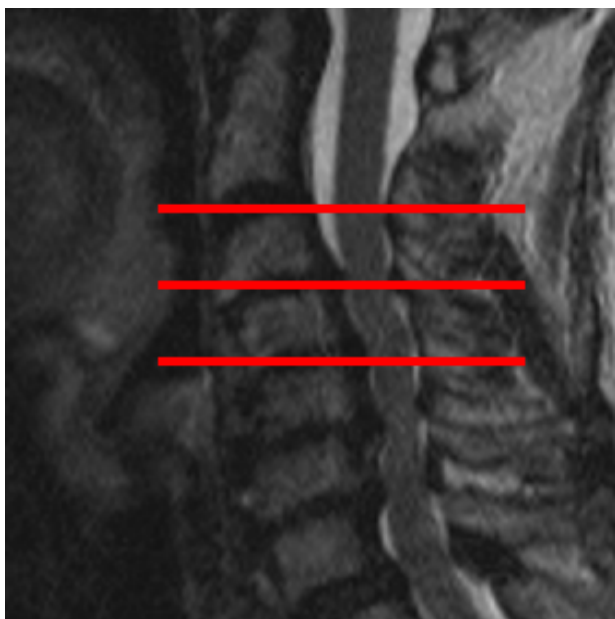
Sagittal T2-weighted MR image of a patient with severe multilevel cervical spondylosis. Analysis of the normal-appearing spinal cord was performed using axial DTI at the C2-3, C3-4 and C4-5 levels (red lines).
